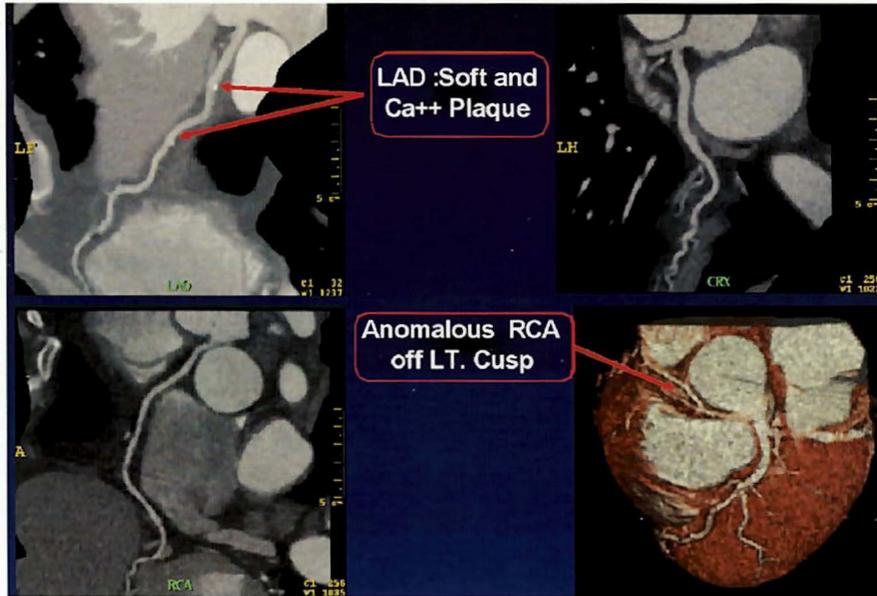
CTA demonstrating an anomalous right coronary artery (RCA) originating from the right coronary cusp and traveling interarterially. The left anterior descending (LAD) coronary artery has mild nonobstructive mixed plaque. Ca++ = calcified. (Images provided by John J. Mahmarian, M.D., F.A.C.C., F.A.S.N.C.)
